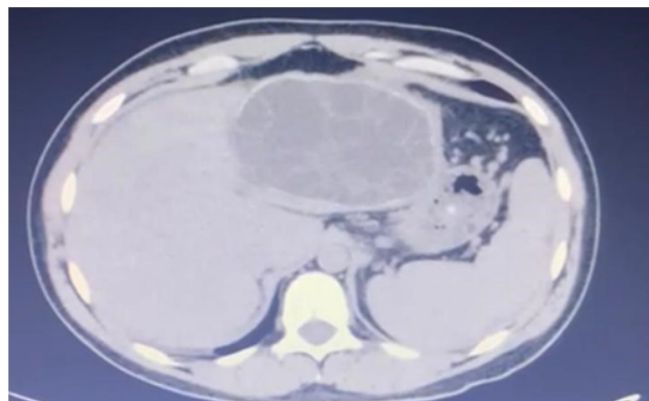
CT scan axial view of the abdomen and pelvis showing large cystic lesion in the left lobe of liver.
